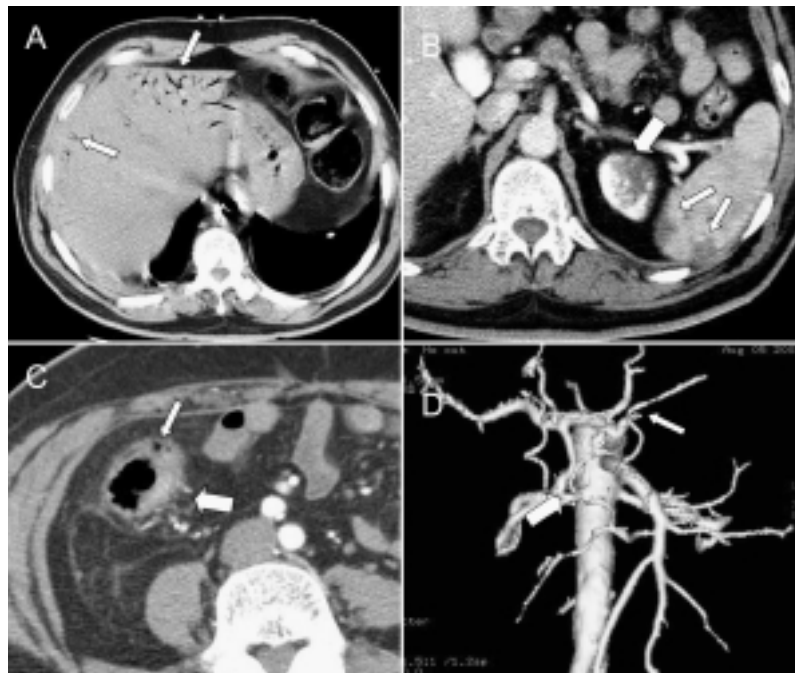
Panel A: unenhanced computed tomography showing tubular areas of decreased attenuation in the periphery of both hepatic lobes (arrows), consistent with the presence of gas in the peripheral branches of the portal vein. Panel B: multiple splenic (small arrows) and renal infarcts (large arrow) are also visible. Panel C: enhanced computed tomography depicting mural thickening of the colon and gas collection inside the walls (small arrow) associated with mesenteric edema (large arrow), consistent with pneumatosis intestinalis. Panel D: three-dimensional reconstruction of computed tomography images showing proximal occlusion of the splenic artery (small arrow). The inferior mesenteric artery is not visible due to thrombotic occlusion (large arrow).
